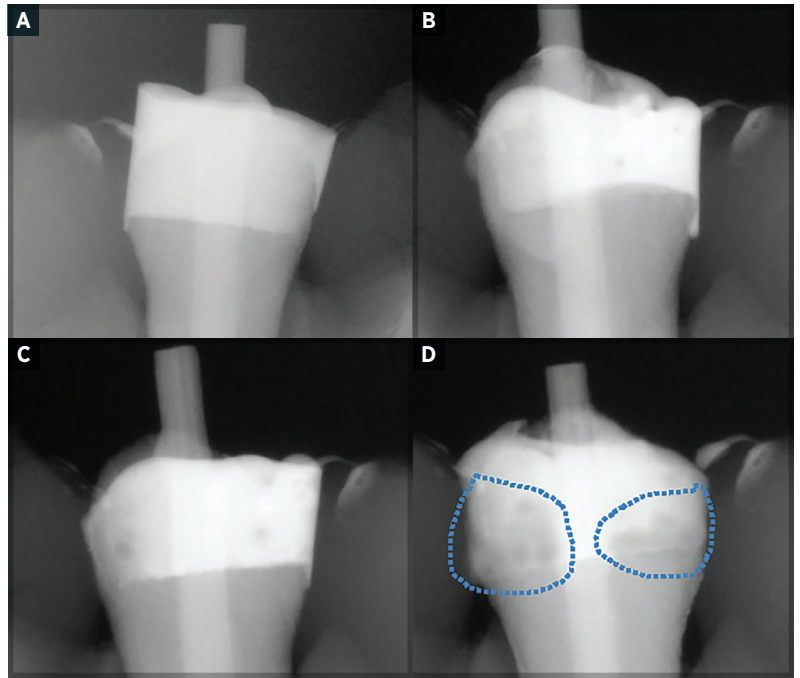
Radiographs representing void severity categories 0 to 3. Blue arrows or dotted lines indicate the presence of voids. A. Category 0. B. Category 1. C. Category 2. D. Category 3.
